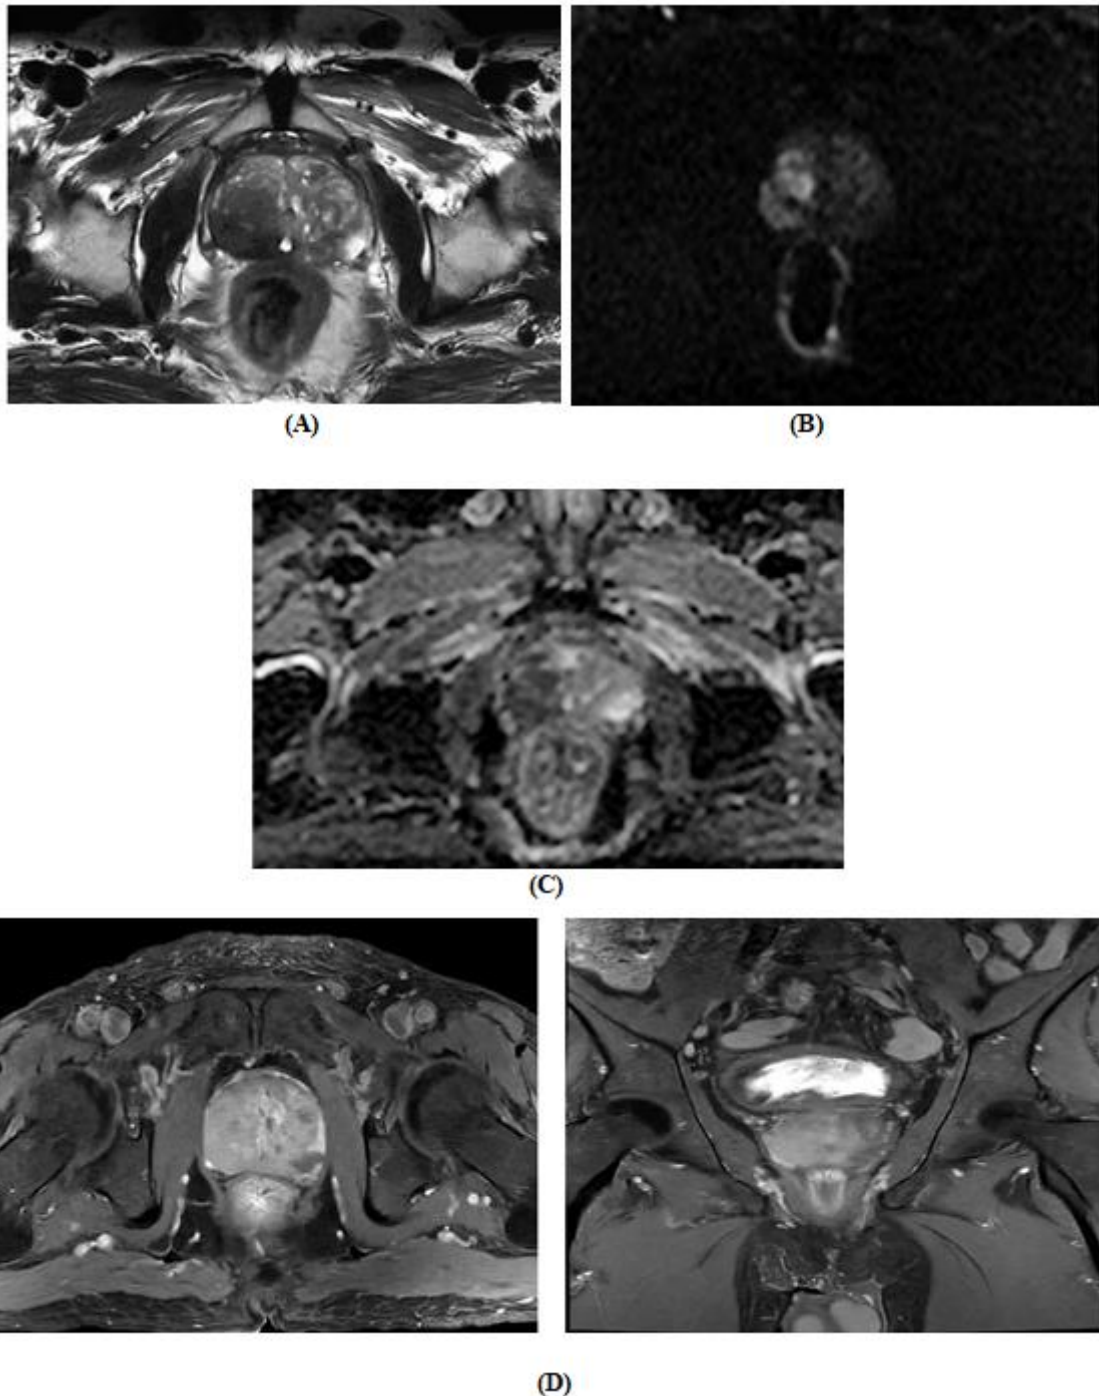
A-T2W axial, B-DWI at b 2000 axial, CADC map axial, Post contrast T1 axial and COR
